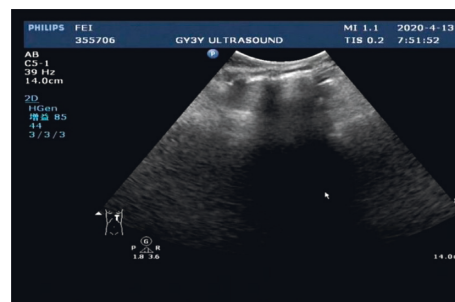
Right congenital cystic adenoid malformation of the lung, CT indicates abnormal changes of the right lung, considering congenital cystic adenomatoid malformation (type I); multiple cystic transparent shadow can be seen in the right lung field, the range is about $57 \times 68 \times 68\text{ mm}$, the boundary is clear, the size of the internal capsule is different, the largest is about $53 \times 48 \times 26\text{ mm}$, a large amount of fluid density shadow can be seen in it, the liquid-gas plane can be seen, and a little normal lung tissue can be seen near the middle lobe of the right lung. Ultrasound revealed a huge cystic echo in the right lung.
